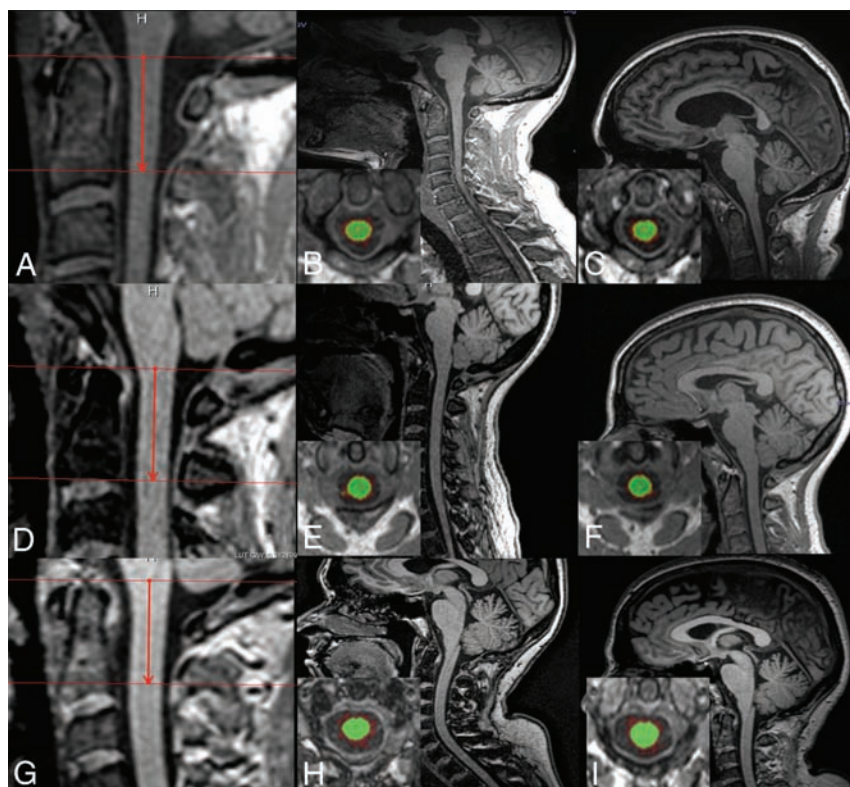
Examples of images from each center (cervical cord and head images). Sagittal T1-weighted MR image of the ROI selection (30-mm section length) in the upper cervical cord, starting at the upper borders of vertebral level C2 (A, D, and G), and sagittal images of the cervical cord and head with representative axial reformat overlaid by corresponding segmentation images from a patient with SPMS from Center A: B, MUCCA cervical cord images = 62 mm², C, MUCCA head images = 64 mm². A patient with RRMS from Center B: E, MUCCA cervical cord images = 74 mm², F, MUCCA head images = 75 mm². An HC subject from Center C: H, MUCCA cervical cord images = 82 mm², I, MUCCA head images = 80 mm².
